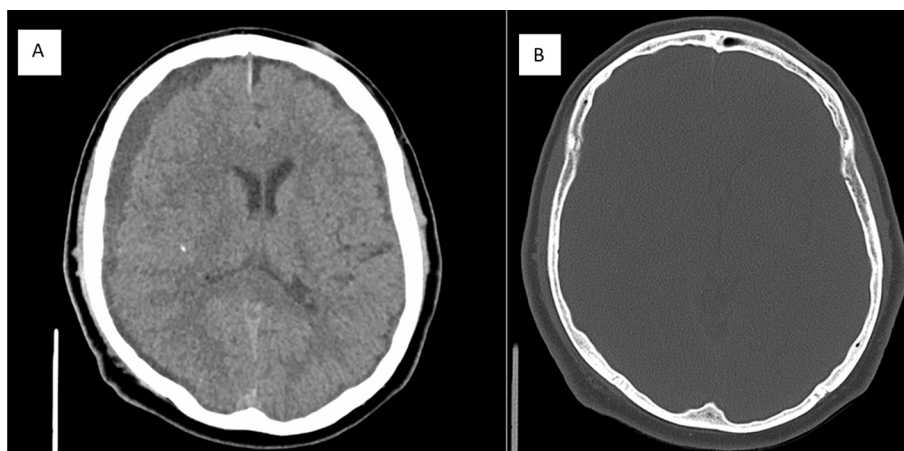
Outpatient head CT from 2 week follow up. [Fig. 1A](#) is a non contrast axial head CT showing the subdural collections have become hypodense with the right sided hematoma exhibiting mass effect. [Fig 1B](#) is the bone window from the same head CT which does not show evidence of a skull fracture.
